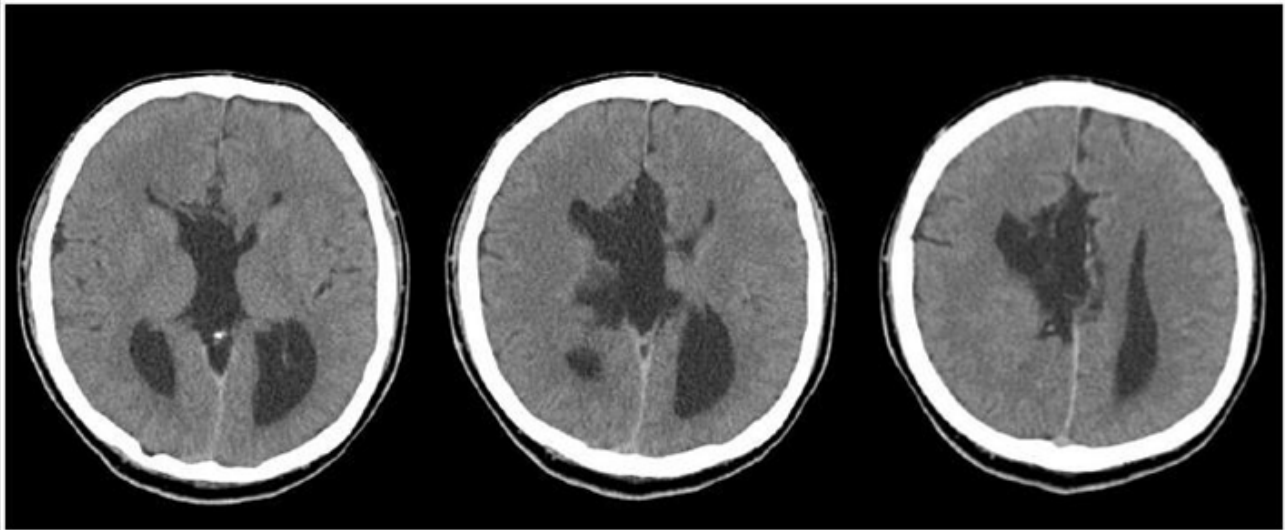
Axial Brain CT.
